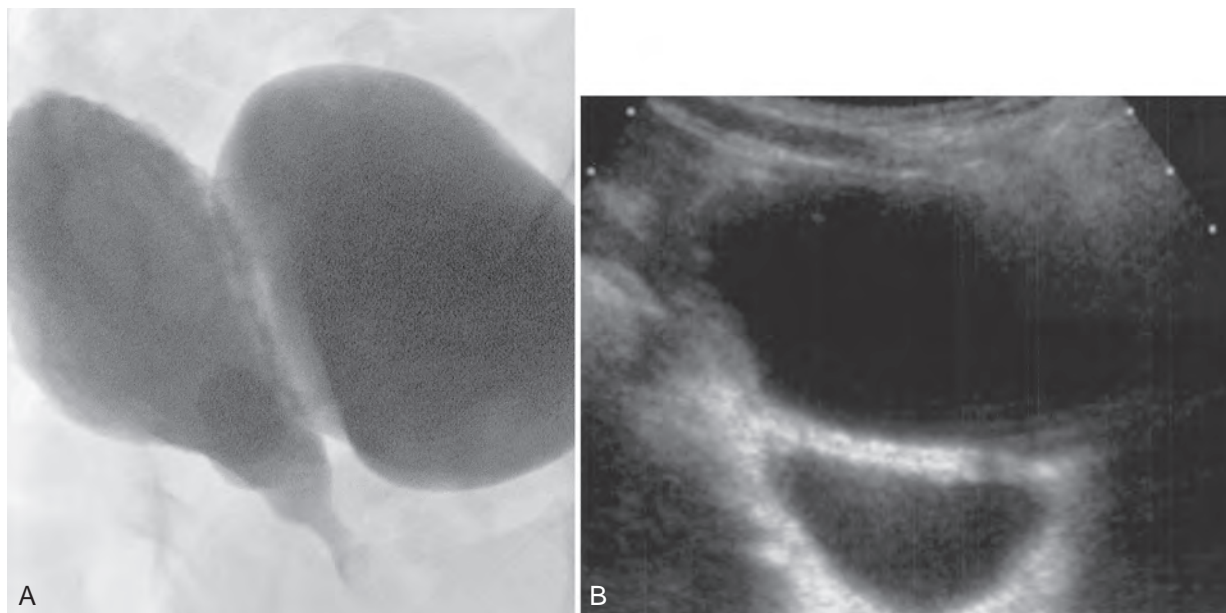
Primary paraureteral diverticulum. A, Vesicoureterogram image of large primary paraureteral diverticulum. B, Ultrasound image of the same diverticulum.
